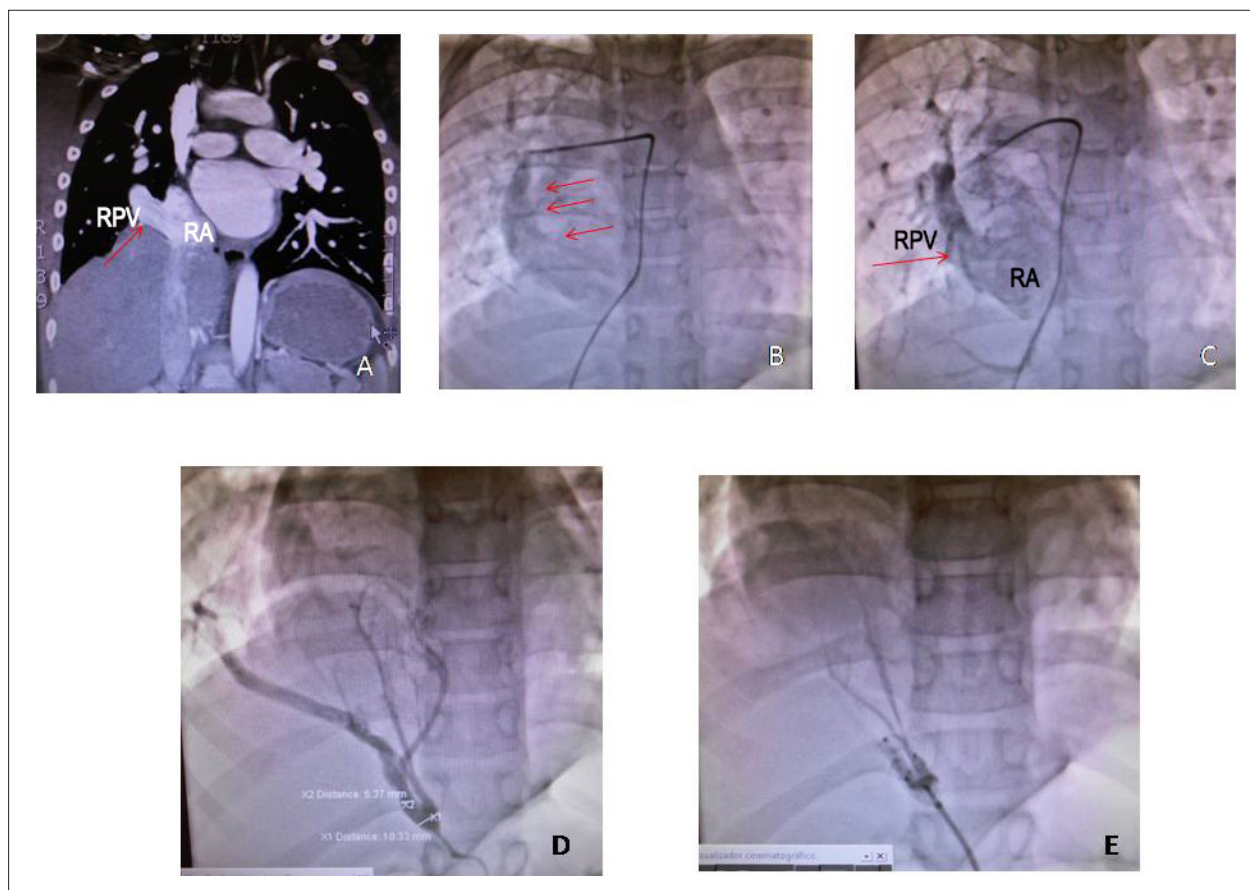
CT angiography in A showing the right pulmonary vein (RPV, arrow) draining into the right atrium (RA); angiography shows the scimitar sign (arrows) of the RPV in B and draining into the RA in C; systemic-pulmonary collateral vessel emerging from the descending aorta into the right lower lobe (pulmonary sequestration) in D and after its embolization in E.
